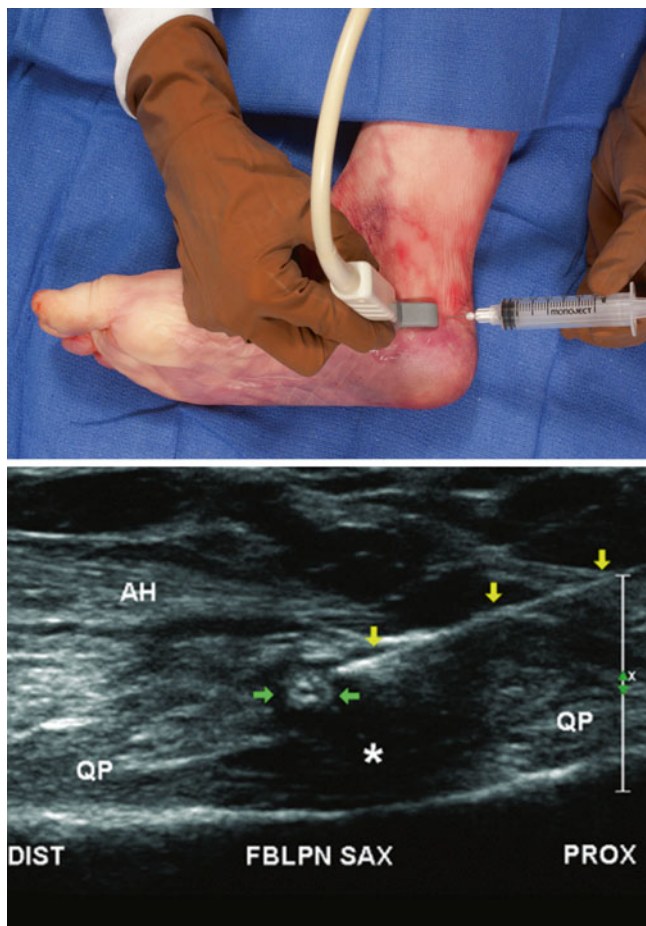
Short-axis sonographic view of the inferior calcaneal nerve. *AH* abductor hallucis muscle, *QP* quadratus plantae muscle, green arrows ICN, * = plantar fascia. The vertical ICN lies between the *AH* and the *QP*. Note the in-plane needle entering posteriorly (From Presley et al. [5]. Reprinted with permission from American Institute of Ultrasound in Medicine)
